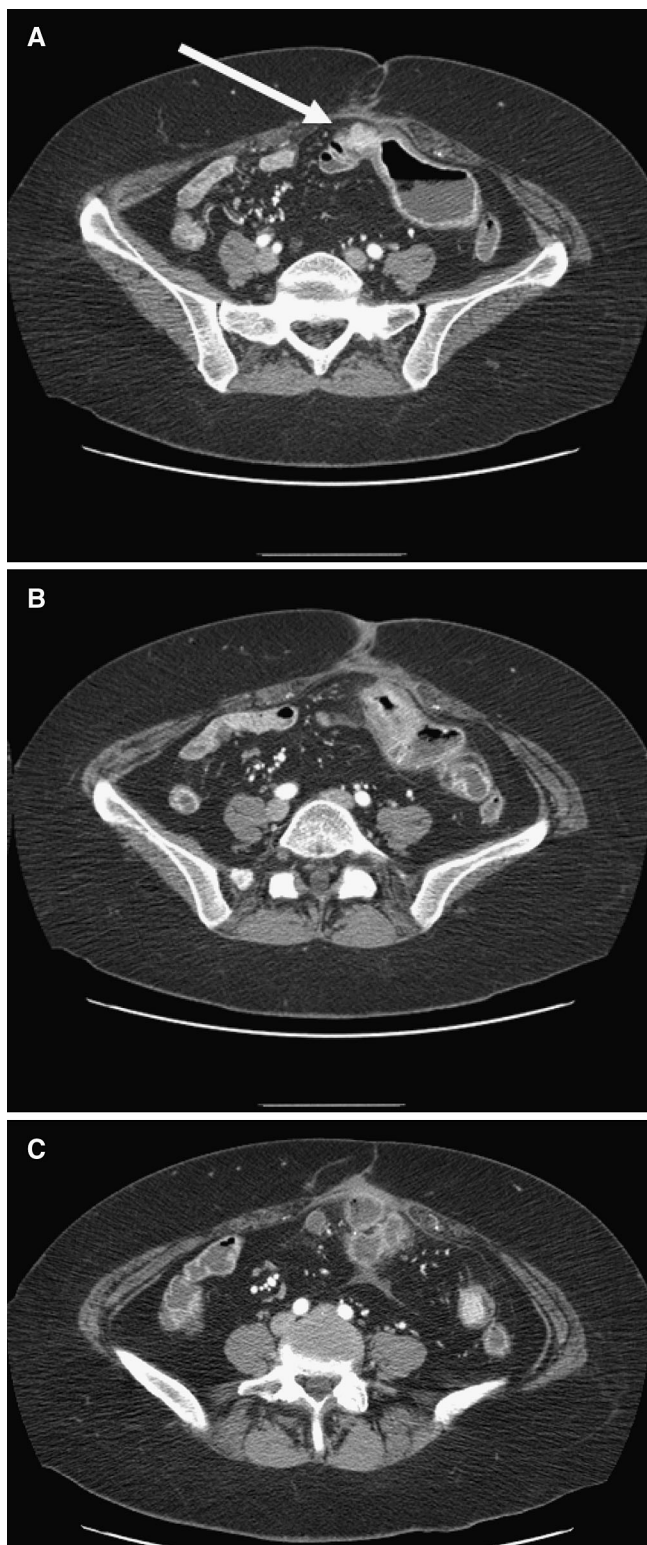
A 54-year-old female patient with Crohn's disease presented with abdominal pain. CT images (A–C) through the abdomen and pelvis demonstrate multifocal small bowel strictures with proximal dilatation. One stricture (*arrow*) has a nodular configuration along the distal end worrisome for adenocarcinoma. This stricture also has a perforation with surrounding abscesses.
